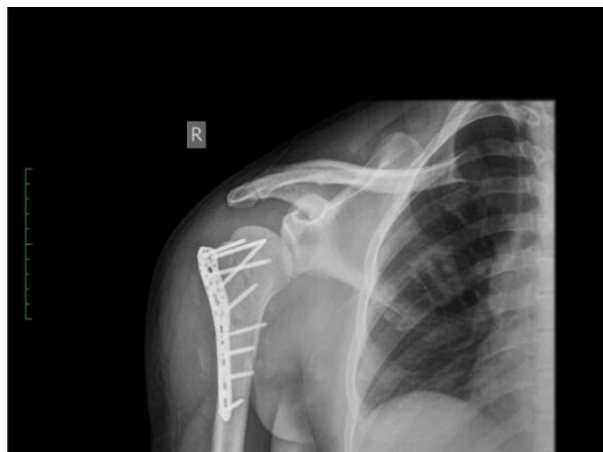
Anteroposterior radiograph of the right shoulder showing inferomedial displacement of the head of the humerus from the glenoid fossa, consistent with an anterior dislocation. A 3-part fracture of the proximal humerus is also seen with displacement of the greater tuberosity and shaft.
